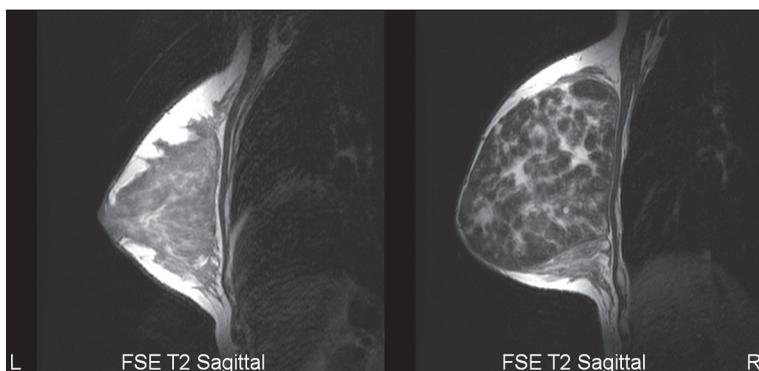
Patient E-B, MR of both breasts, FSE T2-weighted sequence, sagittal slices – large well circumscribed tumor of the right breast with inhomogeneous signal.
